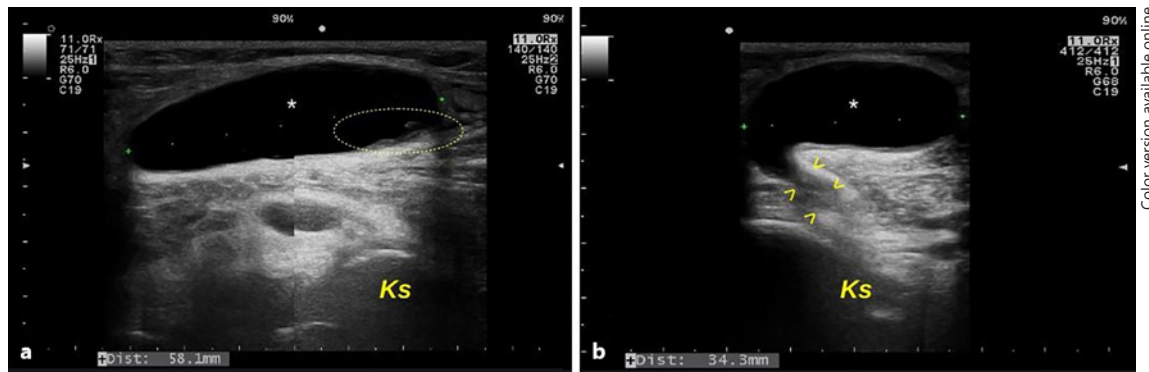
Longitudinal (a) and transverse (b) ultrasonographic scans of the posterior aspect of the knee. a A fair amount of synovial fluid (*) is present in the BC. Hypo-echoic material (circle) is observed near the cystic wall. b In the connection with the knee articular space (Ks) can be appreciated (arrowheads). Green lines = longitudinal and transverse dimensions.
